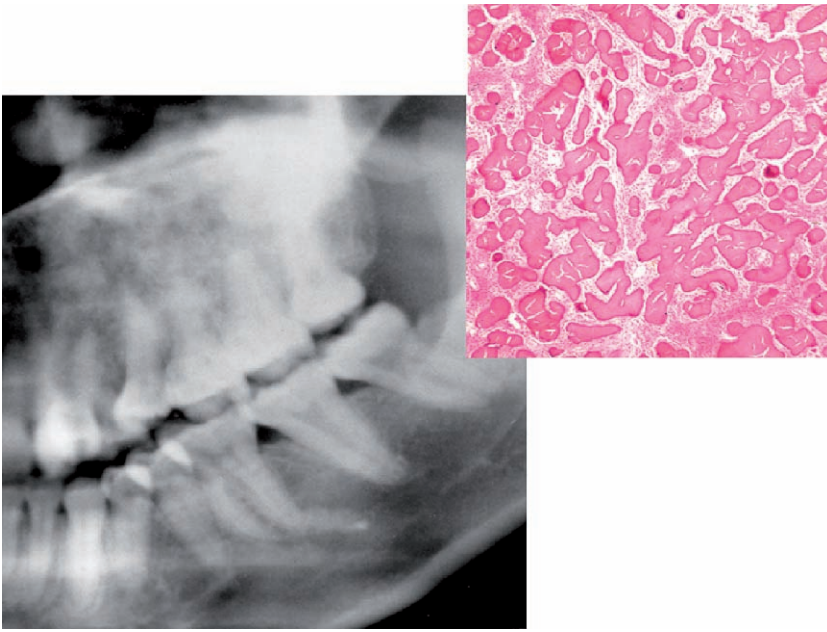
Fibrous dysplasia: cropped panoramic radiograph showing mature (late) lesion of the left maxilla, obscuring the sinus. The lesion is radio-opaque with some radiolucent mottling. It has a ground (frosted) glass appearance. The lesion melds with the normal surrounding bone
